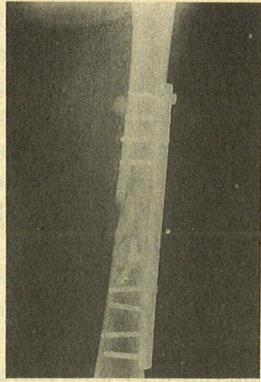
Immediate post-operative radiograph following internal fixation of comminuted fracture femur along with application of allograft bone paste. The allograft is seen as a mass of bone with indistinct margins. The bone paste has a lower density as compared to host bone.
